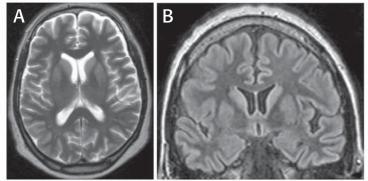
A. axial T2W and B. coronal FLAIR sequences demonstrate hyperintensity of the basal ganglia (putamen and caudate head).
